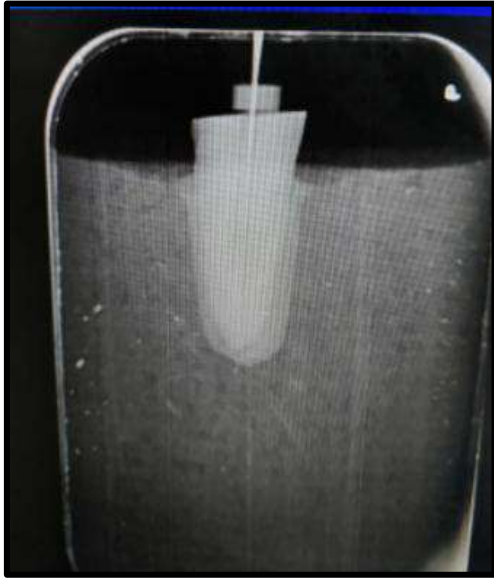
Radiograph demonstration of working length
